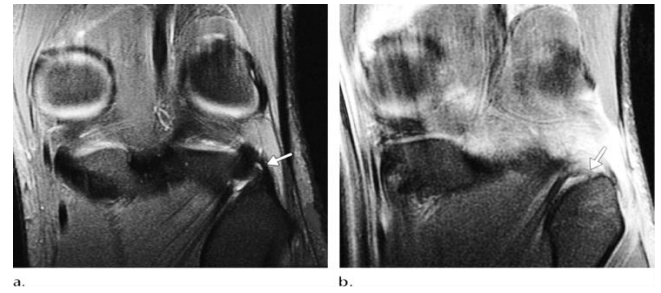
Normal PFL and PFL tear. (a) Coronal proton-density-weighted fatsuppressed MR image in a 27-year-old woman shows an intact PFL (arrow) extending from the myotendinous junction of the popliteus to the medial aspect of the fibular styloid process. (b) Coronal proton-density-weighted fat suppressed MR image in a 20-year-old man shows, in contrast, increased intrasubstance signal intensity within the PFL (arrow) and surrounding soft-tissue edema, which are consistent with a partial tear (28).
